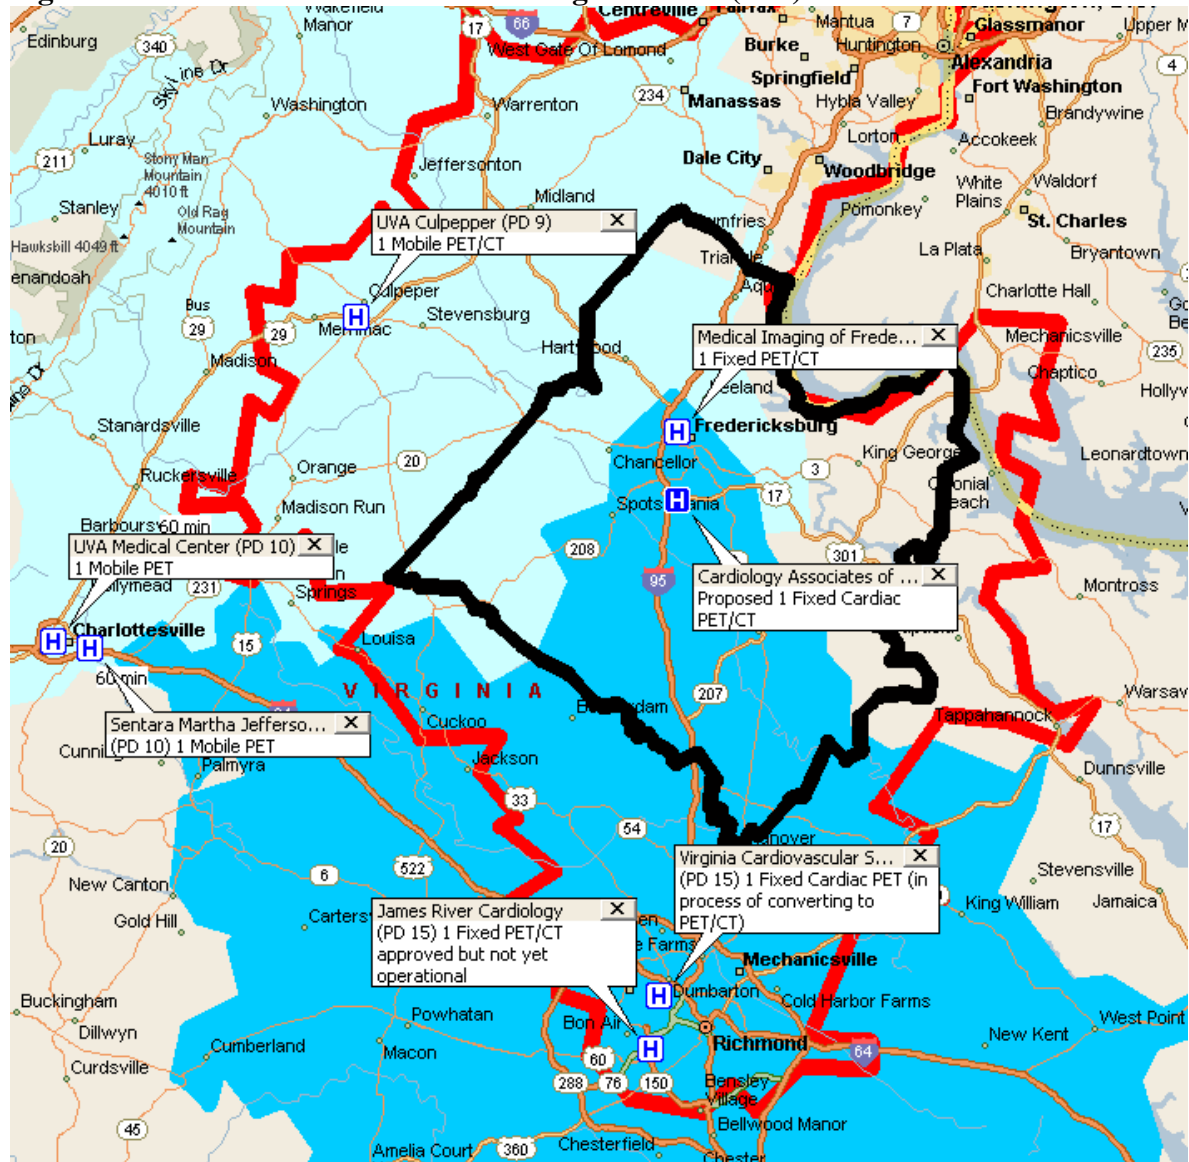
PD 16 PET/CT Locations
